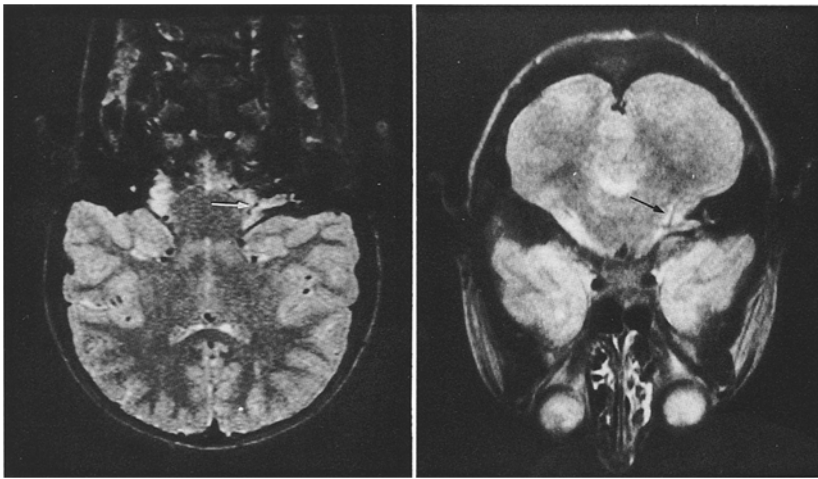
Transverse and coronal T2-weighted images (TR 2100, TE 100) show an anomalous vascular structure in the right cerebellopontine angle cistern (arrow)
